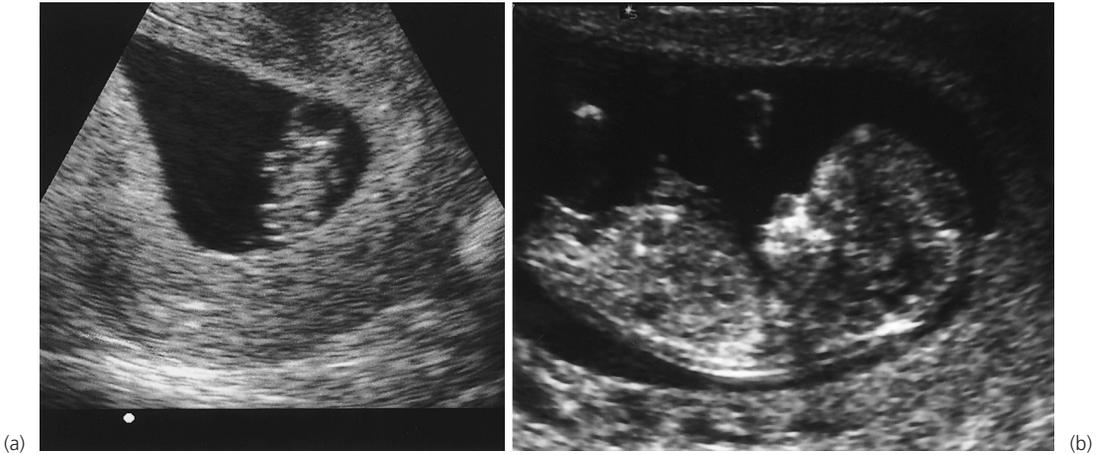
Different stages of fetal growth. (a) Ultrasound showing a sac at 7 weeks. (b) Ultrasound showing a sac and fetus at 12 weeks.
